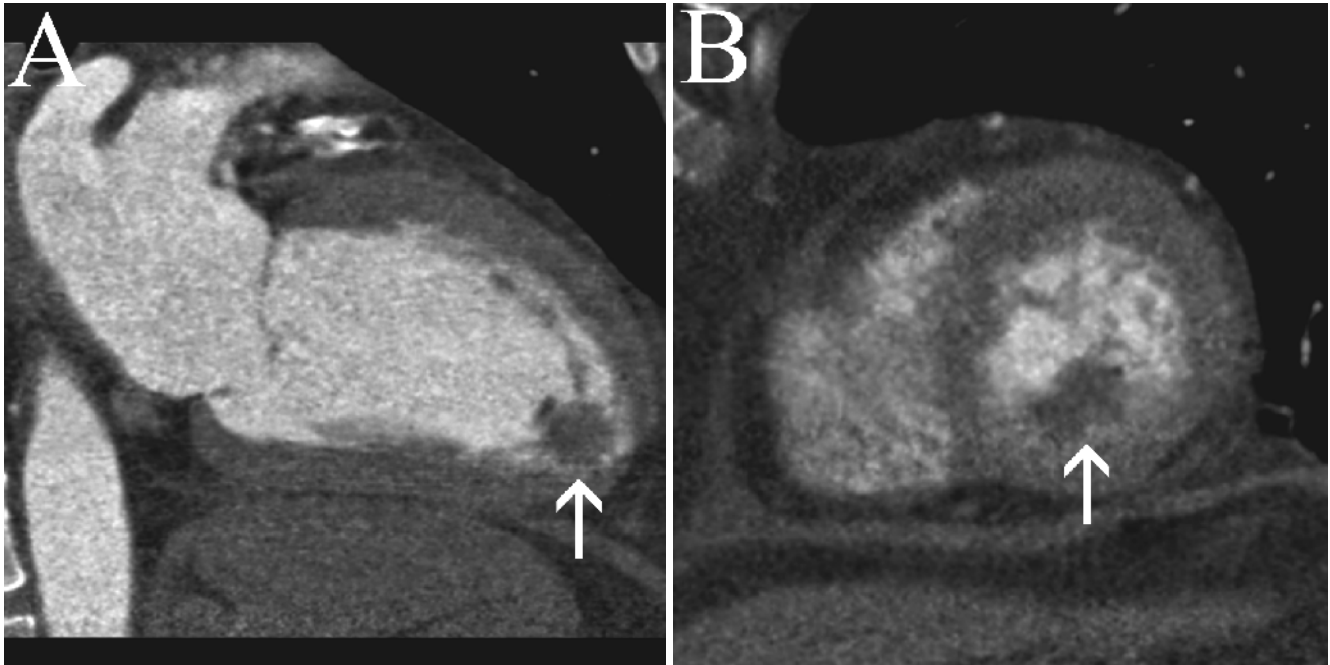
Forty-five-year-old woman with a recent myocardial infarction. Four-chamber (a) and two-chamber (b) views from a cardiac CT show a left ventricular apical aneurysm with thrombus (white arrowheads).
